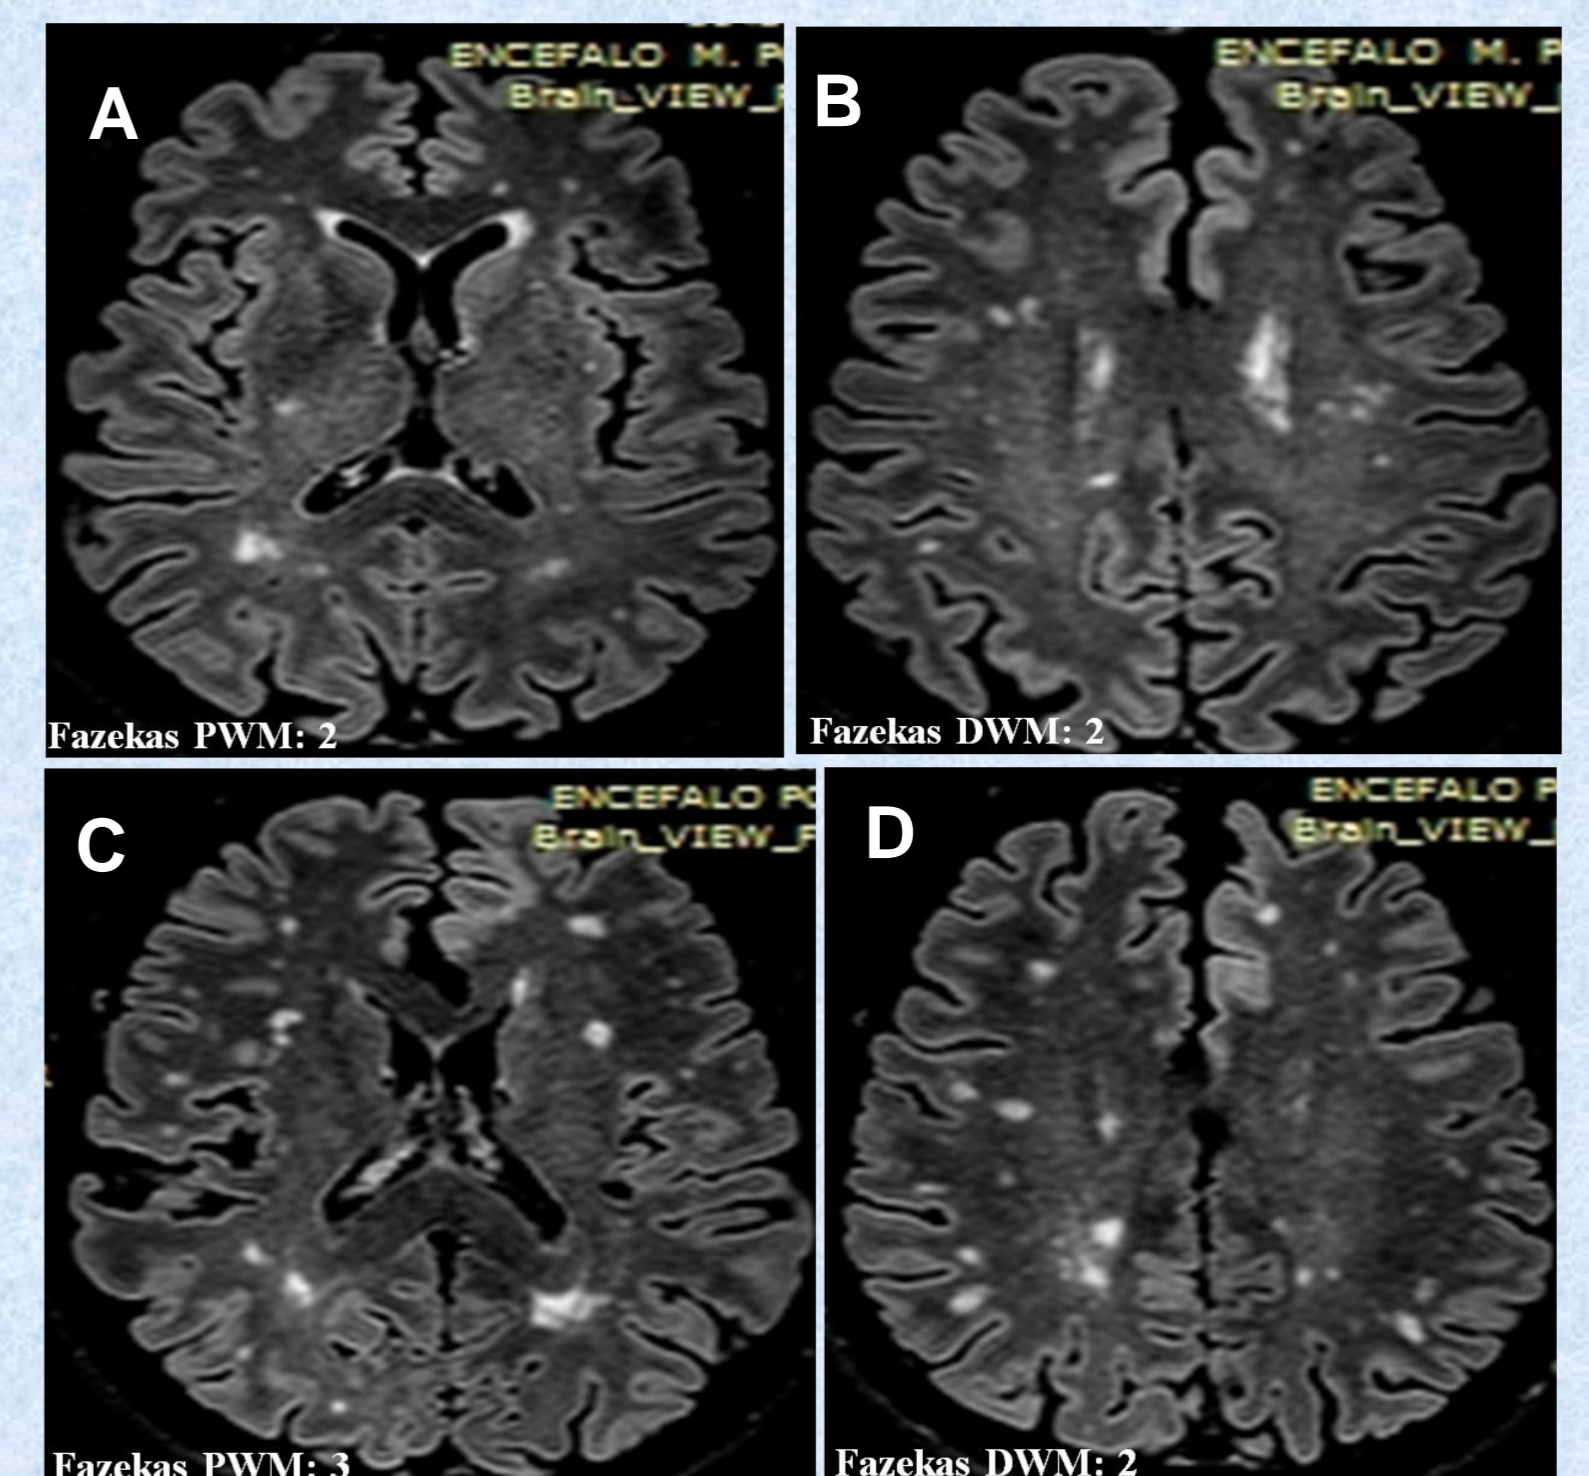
Brain MRI:T2-weighted seq: A, B: pt. 18 (F/63), C, D: pt. 14 (F/56: presence of several gliotic lesions
